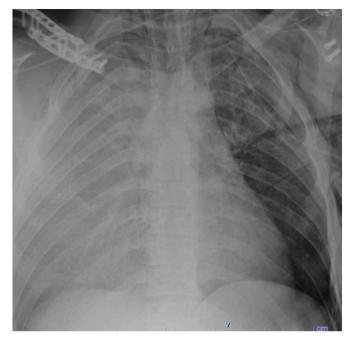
Chest X-ray of case one demonstrating right chest whiteout.
